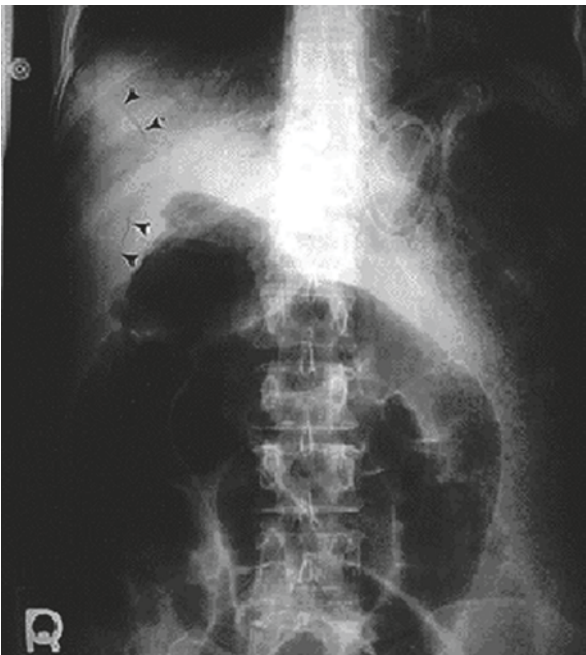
Abdominal X-ray: air in portal veins (*arrowheads*)
